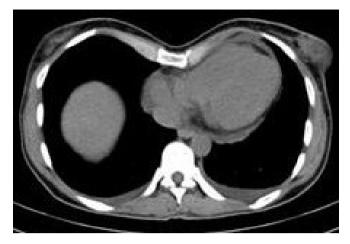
Computed tomography (CT) scan showing small-sized pericardial and bilateral pleural effusions.
